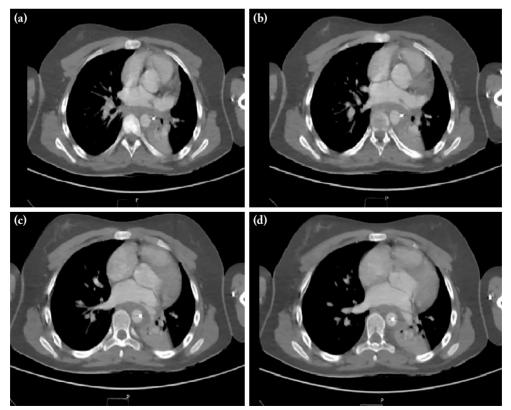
Computed tomography of thorax revealed the scarf pin penetrated the thoracic aorta.
